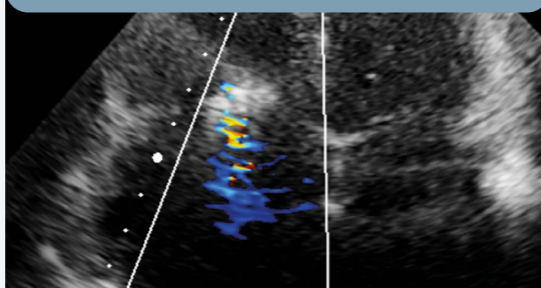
Transthoracic echocardiogram at Day 35 follow-up (four-chamber view).
